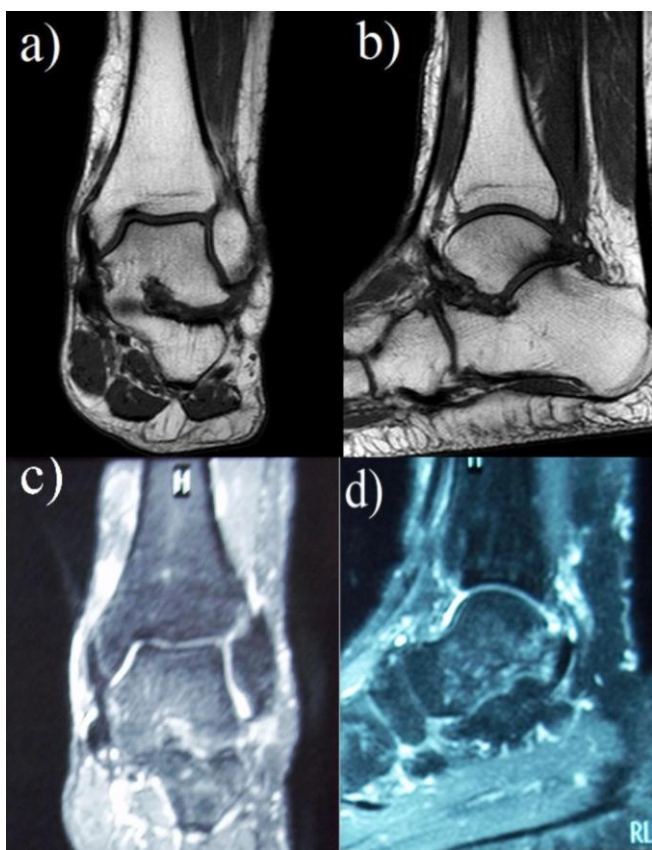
Coronal (a), sagittal (b) T1-weighted and fat-suppressed proton density-weighted coronal (c) and sagittal (d) MRI images at the 3-year follow-up. Increased signal intensity consistent with bone marrow edema is observed in the ventral subchondral area of the talus and on the inferior surface adjacent to the calcaneus, more prominent on proton density-weighted sequences.
